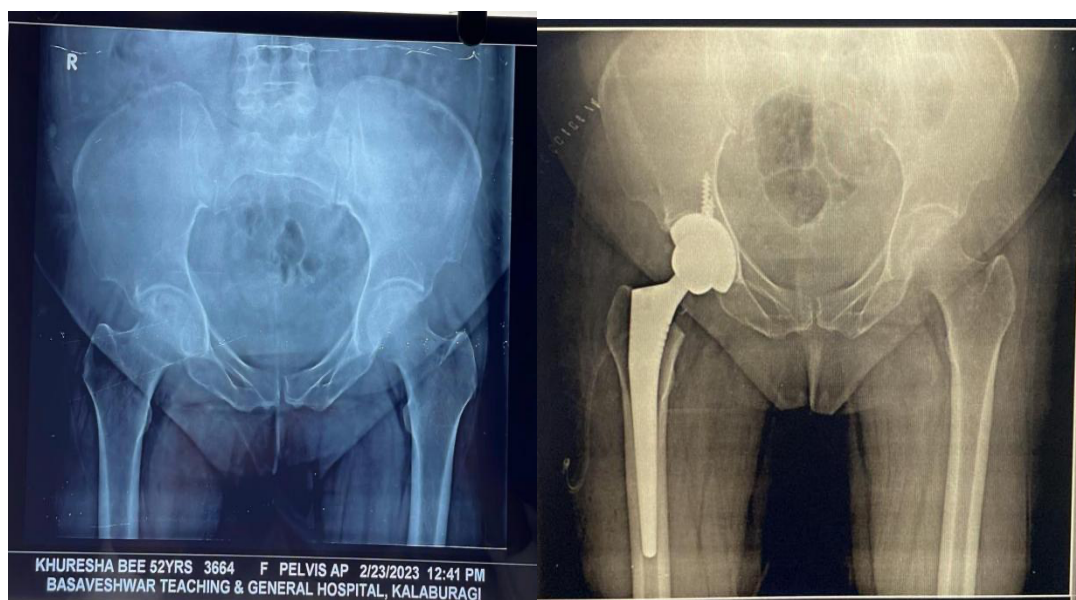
X-ray pelvis of 52 years female showing pre-op and post-op
